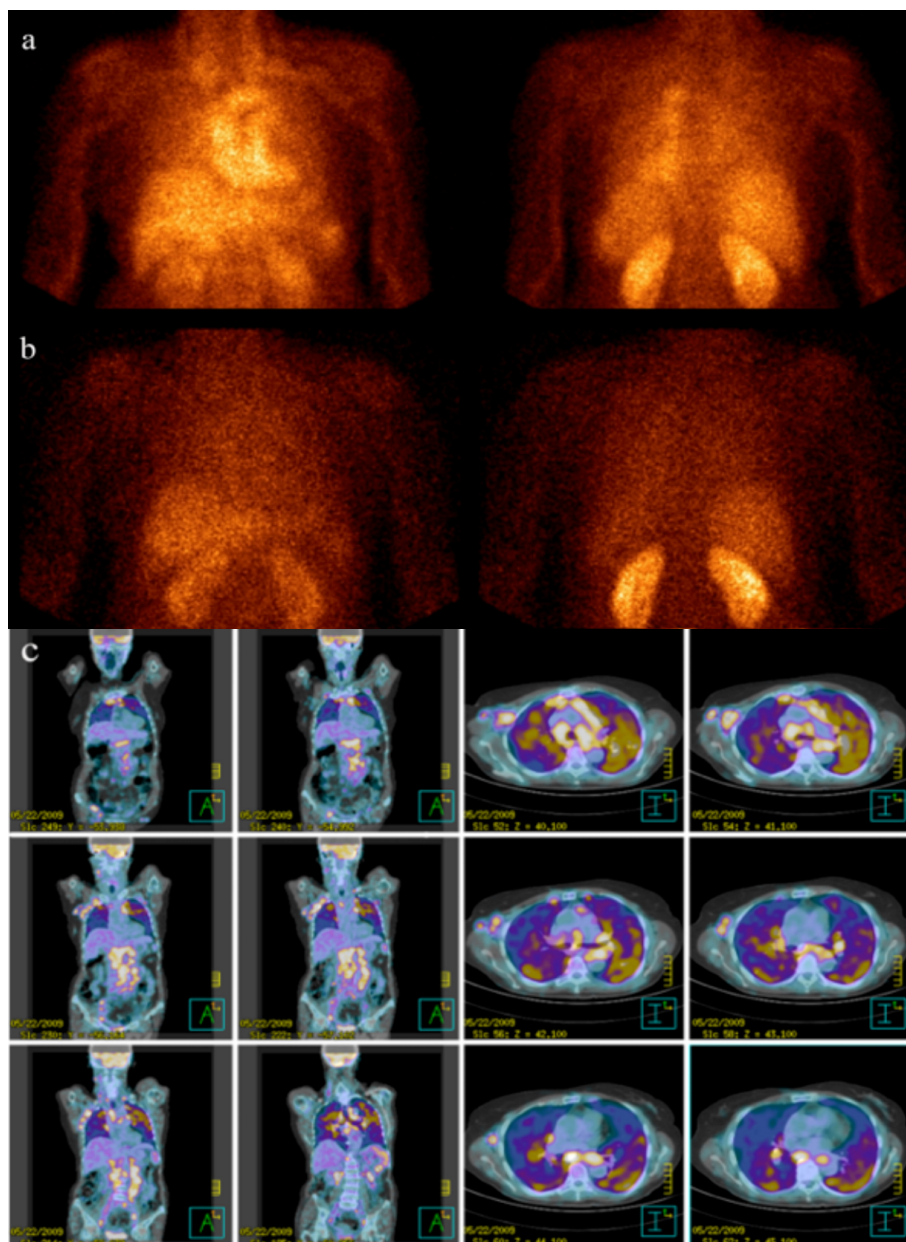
^{99m}Tc -Infliximab scintigraphy of a sarcoidosis patient (patient 3/F) acquired at 6 h (anterior and posterior views, a) and at 24 h (anterior and posterior views, b) showing a moderate and diffuse uptake in the lung parenchima. ^{18}F -FDG-PET/CT images of the same patient showing a focal/hyleal uptake (coronal and transaxial sections, c).
